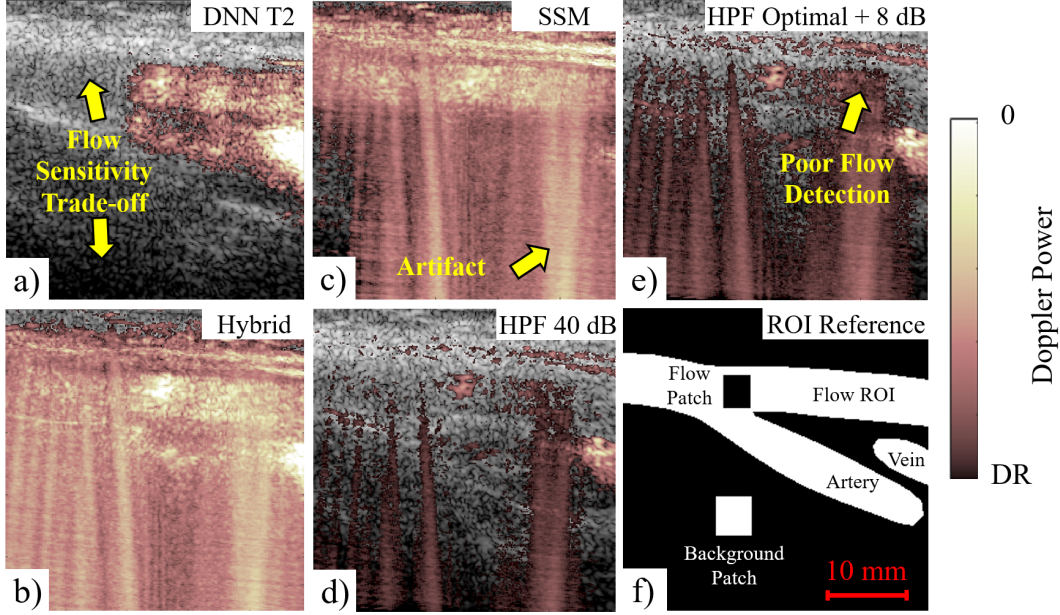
Power Doppler acquired during diastole where weak flow can just be resolved in the upper branch (Frame 254). Flow in the femoral vein is visible. *a)* The proposed DNN SVD clutter filter using the T2 sensitivity threshold, *b)* Hybrid method, *c)* SMM correlation method, and *d)* and *e)* high-pass FIR filter. Panes *a)* - *c)* are presented under 20 dB dynamic range. Pane *d)* is presented under 40 dB dynamic range. Pane *e)* has been rescaled to a DR of 33.7 dB DR relative to the maximum pixel intensity. In this case an additional 8 dB of dynamic range was added to show the poor flow detection in the bifurcation of the high pass filter. Pane *f)* shows an example segmentation of the total flow region and the flow and background ROIs. The proposed filter correctly identifies the femoral vein and some flow in the upper and lower branches but fails to detect flow higher up the artery, marked by the yellow arrow.
